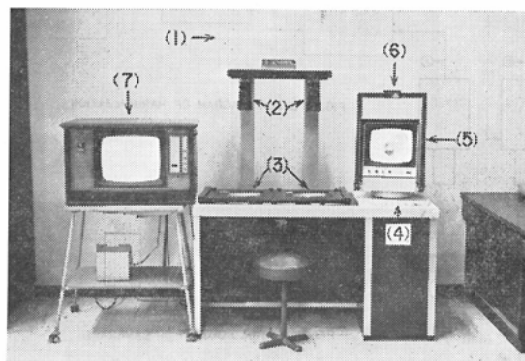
Television X-ray film viewer.
